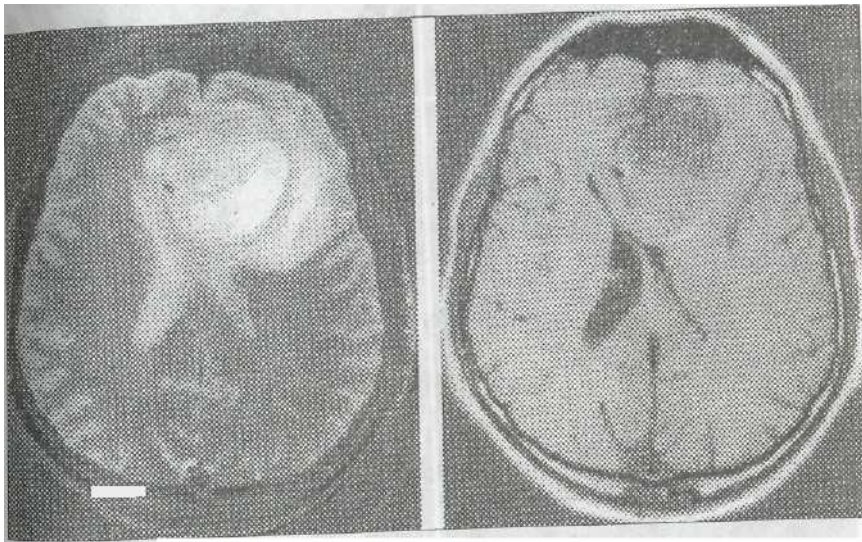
MRI. Glioblastoma of the left frontal lobe
